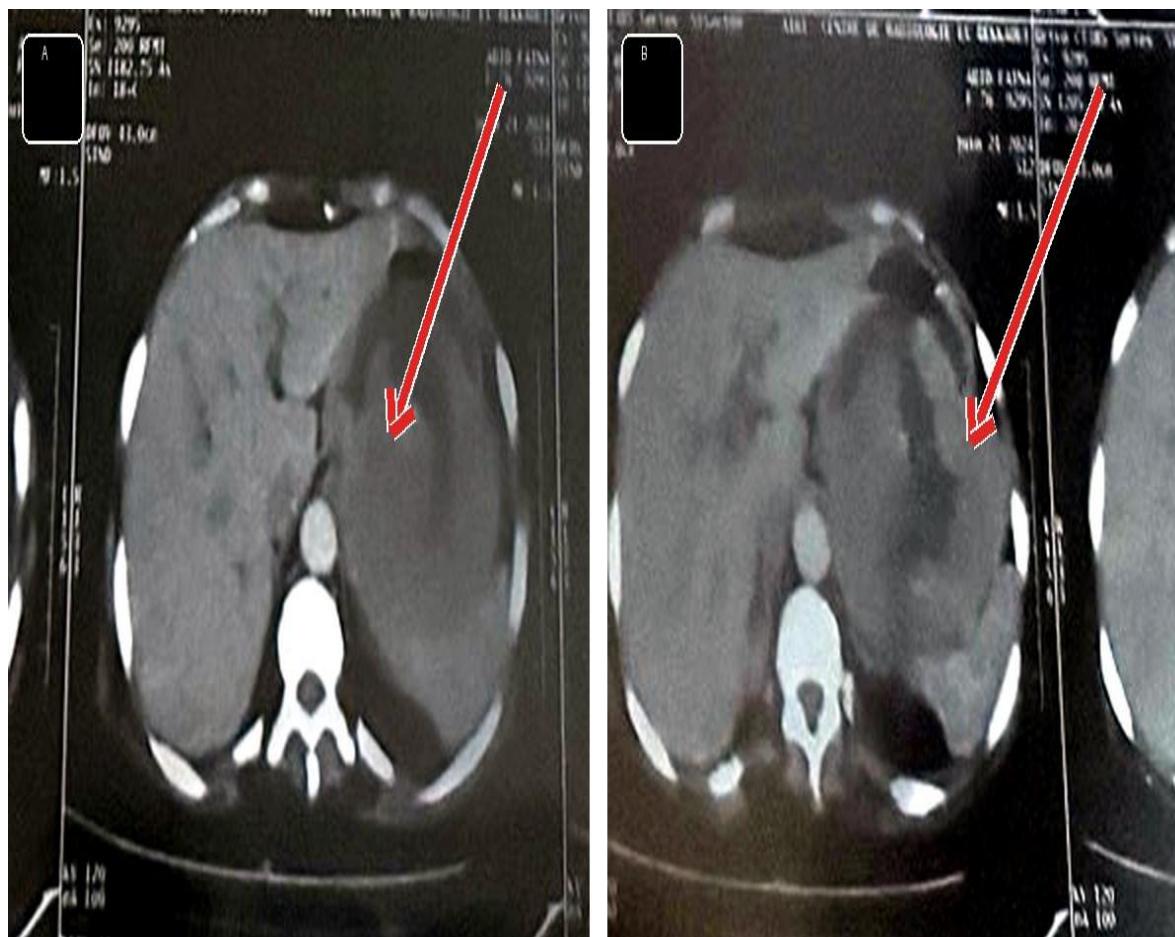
Representative axial contrast-enhanced CT images showing the large heterogeneous left upper abdominal mass centered on the gastric fundus and greater curvature, with necrotic change.
